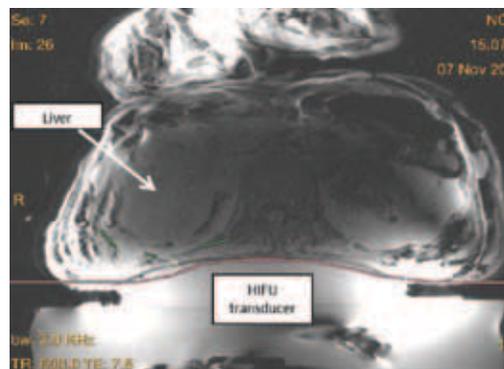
MRI image (Axial). Scan parameters: FSPGR, BW=2 kHz, TE=7.5msec, TR=600msec.
